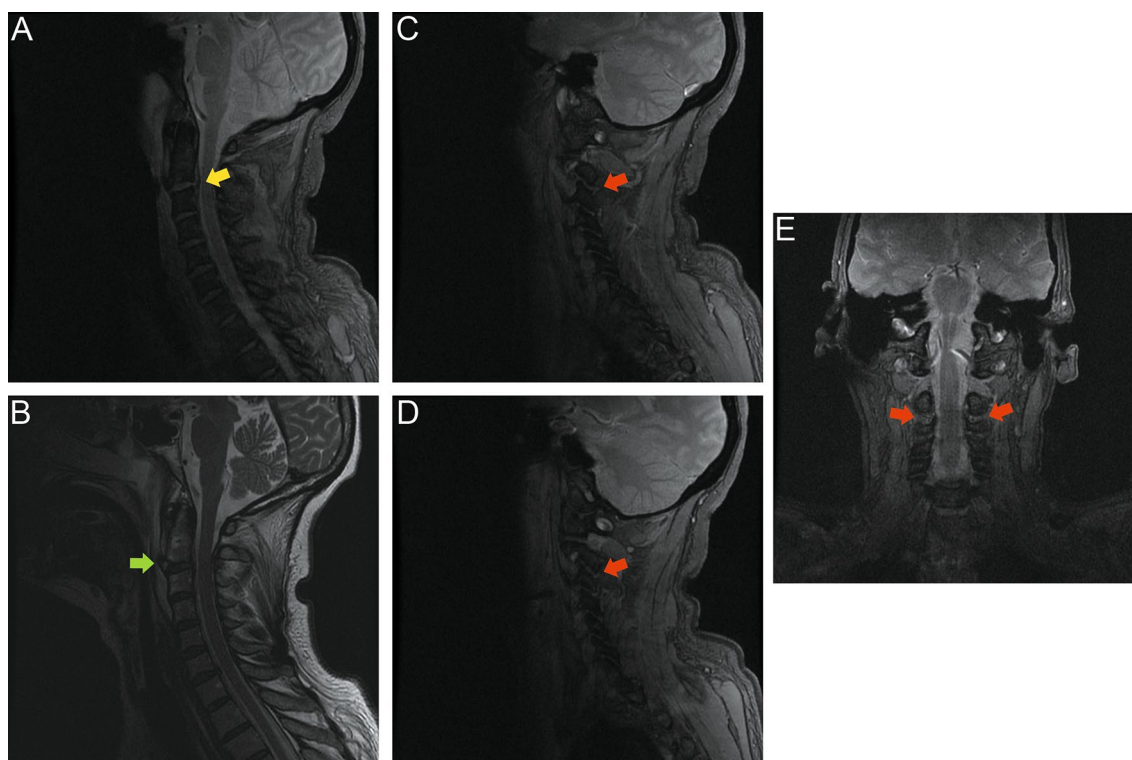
MRI of the cervical spine. a Coronal MERGE image demonstrated epidural hematoma. b T2-weighted sagittal image revealed focal disruption of the anterior longitudinal ligament in C2–C3
